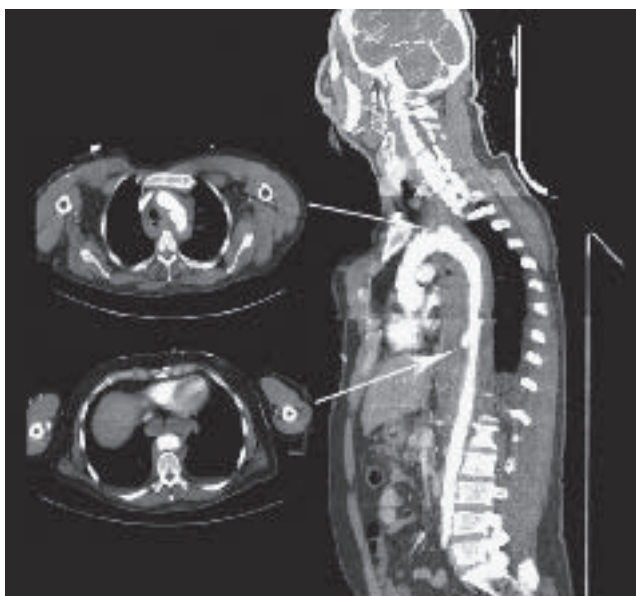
Double rupture of the thoracic aorta at the isthmus and at the diaphragm in a 46-year-old male patient after a fall from 12 m height, who was transferred in hemodynamically unstable condition. Sagittal CT reconstruction and CT scans on admission to the trauma unit show the contained rupture at the isthmus and disruption at the diaphragm with extensive hematoma in the lower mediastinum.
